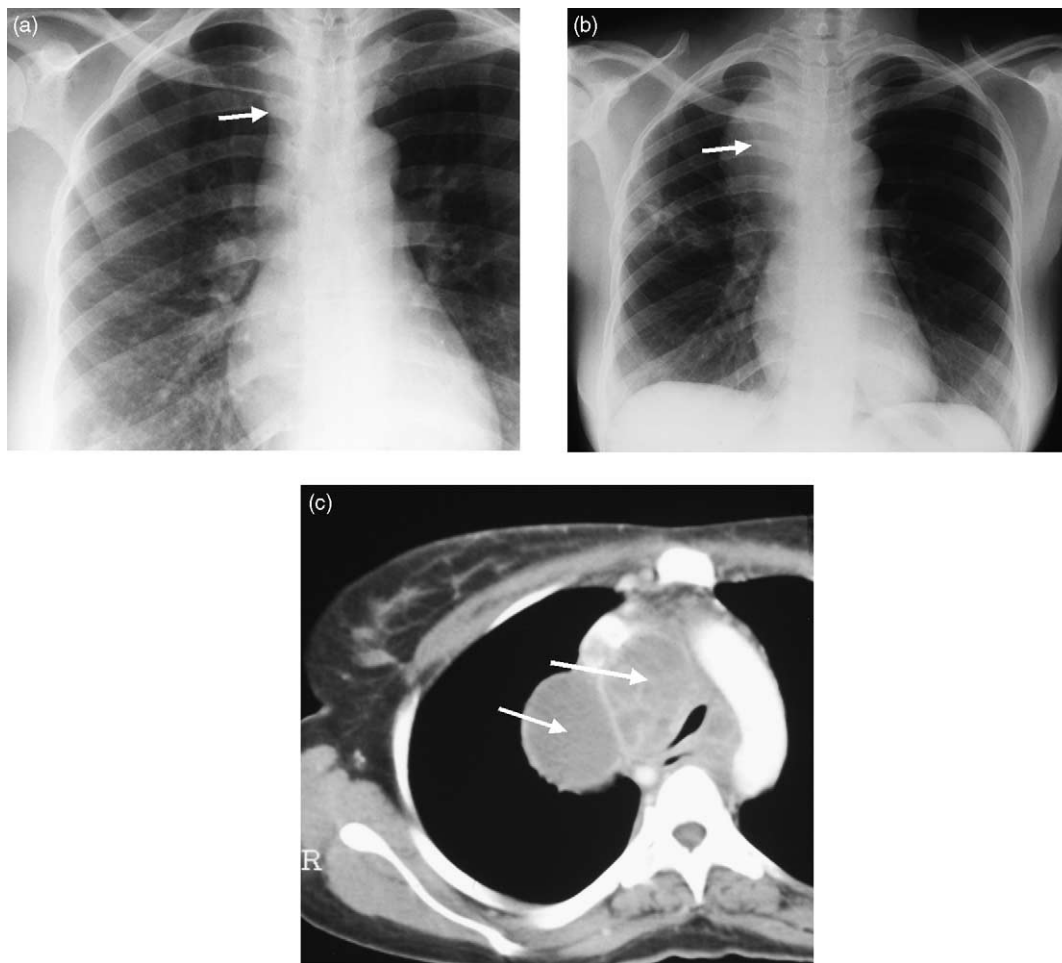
Immune reconstitution disease associated with *M. tuberculosis*. (a) Chest radiograph of an HIV-infected patient showing right paratracheal lymphadenopathy (arrow) and a reticulonodular infiltrate due to *M. tuberculosis* infection. (b) After 2 months of anti-TB therapy and HAART, the patient presented with stridor. A repeat chest radiograph shows massive right paratracheal adenopathy (arrow) displacing and compressing the trachea, minor right hilar adenopathy and a nodular infiltrate in the right mid-zone. (c) Computed tomography shows enlarged lymph nodes in the right paratracheal region (arrows) causing displacement and marked compression of the trachea. (Reproduced with permission from [51]).
